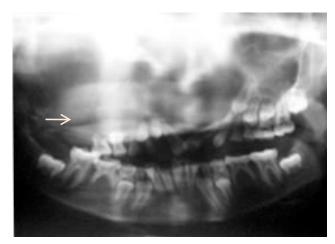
Panoramic radiograph showing diffuse radiopacity at right maxilla obliterating maxillary sinus (arrow).
